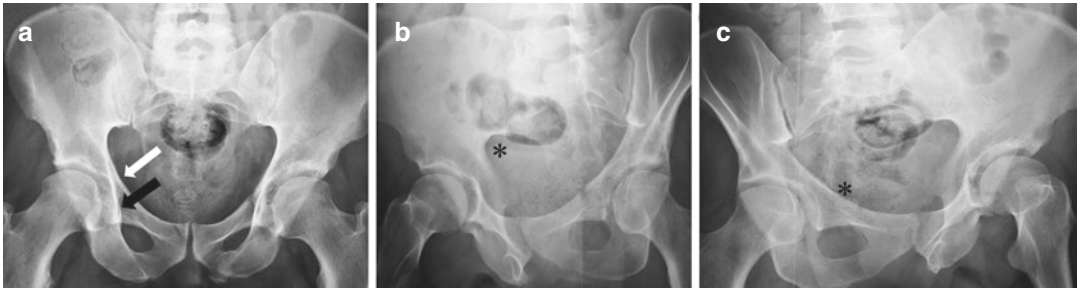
(a–c) X-ray AP projection (a), iliac oblique view (b), and obturator oblique view (c) (projections of Judet). These three projections allow to identify the radiographic references of the two columns that are the iliopubic line as anterior column landmark (*white arrow* in a) and the ilioischial line as posterior column repere (*black*
